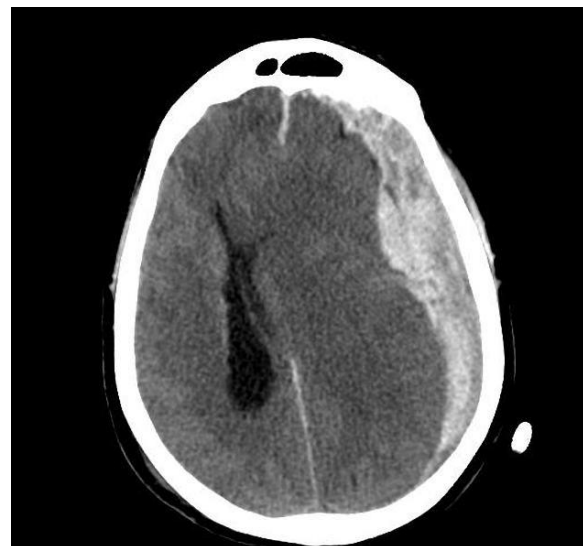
axial CT of a subdural hematoma
